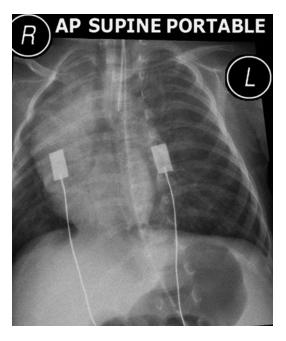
Malposition of endotracheal tube. Esophageal malposition of an endotracheal tube. Oblique frontal chest radiograph confirming inadvertent intubation of the esophagus with an endotracheal tube posterior to the airway
